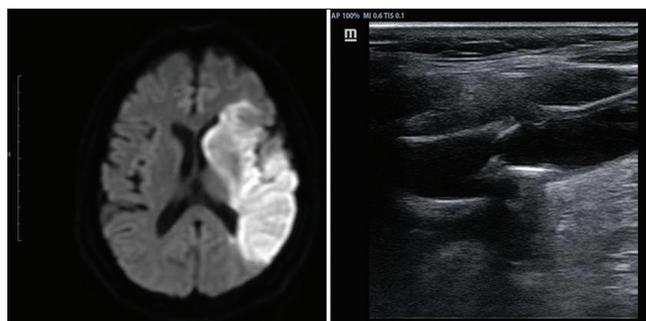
Magnetic resonance imaging-diffusion-weighted imaging image shows restriction in the left caudate nucleus, internal capsule, M1, M2, and M3 in middle cerebral artery distribution in a patient presenting with hemiparesis. In a same patient longitudinal grey scale ultrasound images of the left carotid artery shows echogenic plaque giving posterior acoustic shadowing noted in left common carotid artery and causing significant stenosis
